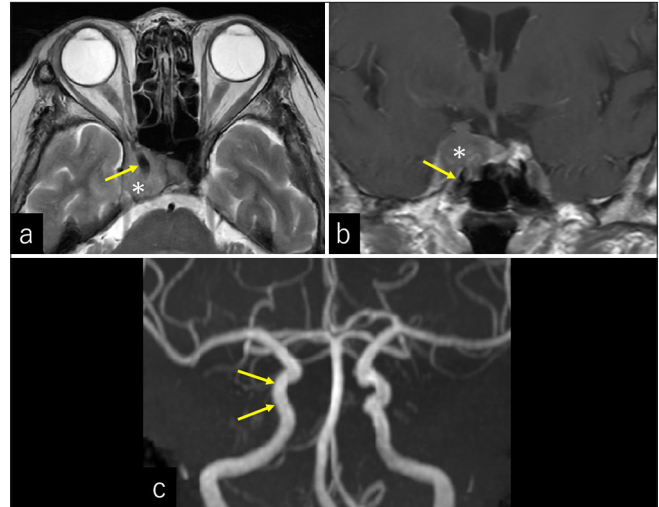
(a and b) Axial (a) T2-weighted and (b) contrast-enhanced coronal T1-weighted cerebral magnetic resonance (MR) images, showing the cavernous portion of the right internal carotid artery (arrow) completely encased by tumor (asterisk). (c) Anteroposterior view of the cerebral MR angiography demonstrating intact flow of the cavernous segment of the right internal carotid artery (arrows).
